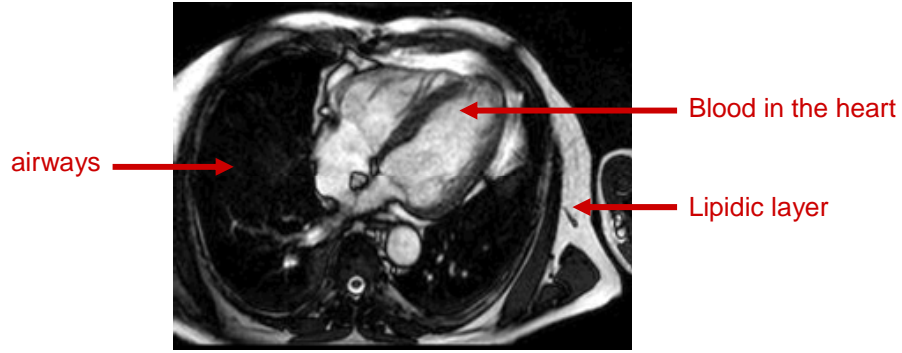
Example of a True-FISP anatomical MRI of the heart in a four chamber view. The heart, blood vessels and the lipidic layer under the skin, all of which are rich in water, appear in white, whereas the pulmonary airways appear in black.
